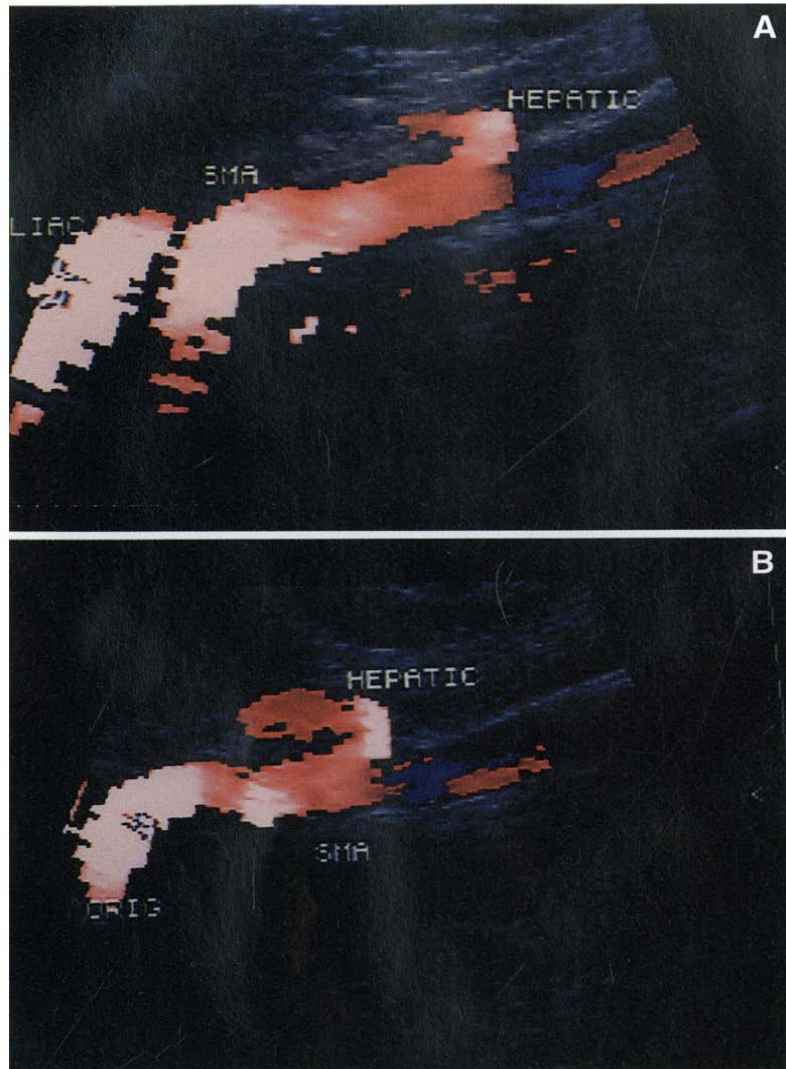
Sagittal view of aorta with both CA and SMA origins identified on a single screen. A, This is a typical starting point for most exams to gain appreciation of proximity and relative location of the vessels. This approach is also useful to avoid misinterpretation of an occasional renal artery that may arise anteriorly from the aorta. In this particular case, an unusually large branch arose from the proximal SMA. PSV in the SMA was normal. The Doppler waveform had no significant spectral broadening, but displayed elevated end-diastolic flow atypical for the SMA in a fasting patient. B, Further evaluation of the branch revealed that it traveled directly to the porta hepatis. Since another artery had been identified originating from the celiac and leading to the porta, the anomalous SMA branch was identified as a replaced right hepatic rather than a replaced common hepatic. Angiography confirmed the findings.
